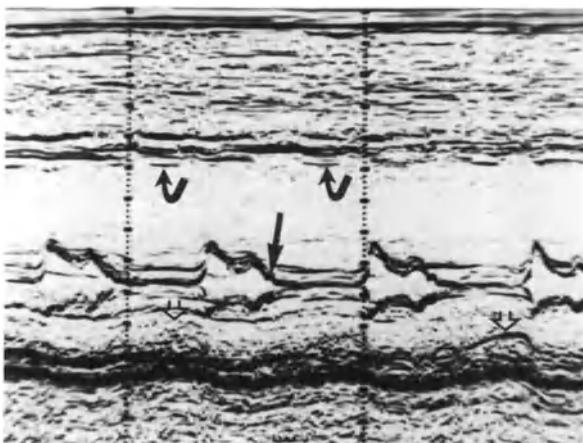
M-Mode echocardiogram from a patient with a poorly functioning, dilated left ventricle showing a characteristic mitral valve appearance with a 'C' hump (straight arrow). Posterior wall (open arrow), interventricular septum (curved arrow).
